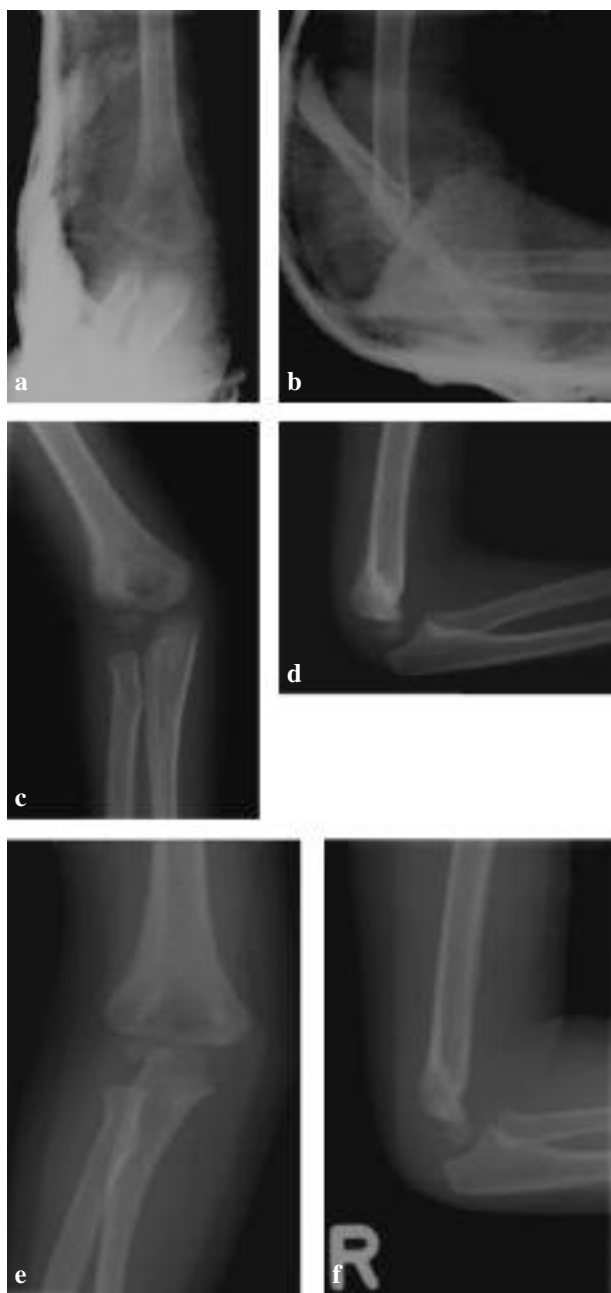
Anteroposterior and lateral radiographs 1 week (a, b), 3 weeks (c, d) and 4 weeks (e, f) after the initial injury ; consolidation in anatomic position.
